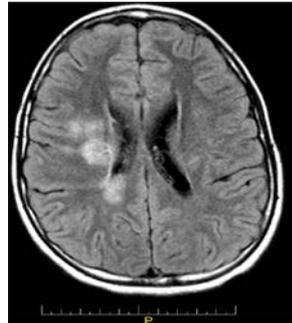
MRI of initial episode of ADEM. T2 FLAIR of brain showed multiple "fluffy" lesions in right periventricular and also cerebellar area (not shown).
